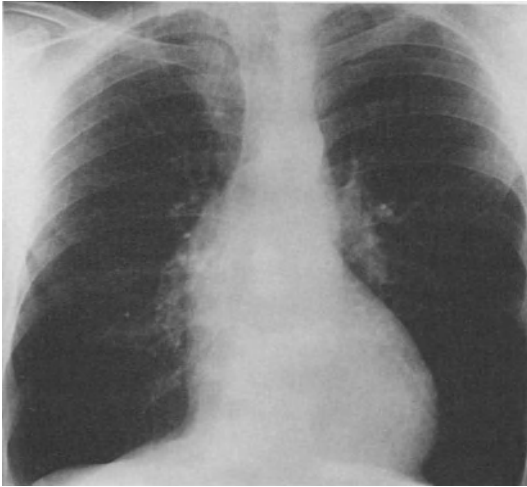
The X-ray in aortic insufficiency demonstrating enlargement of the ascending and descending thoracic portions of the aorta. There is also moderate left ventricular hypertrophy.
